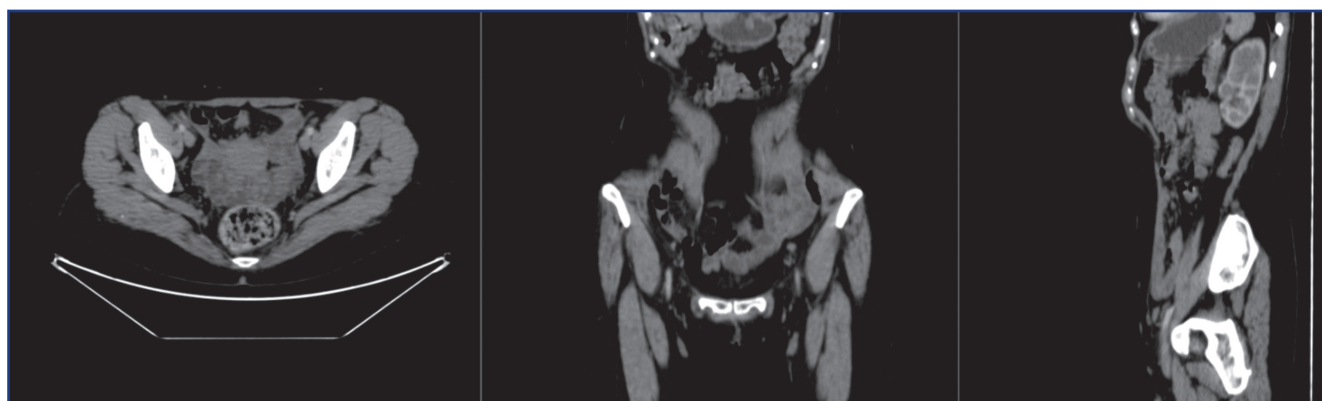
CT of the chest, abdomen and pelvis with intravenous contrast on September 23, 2024
